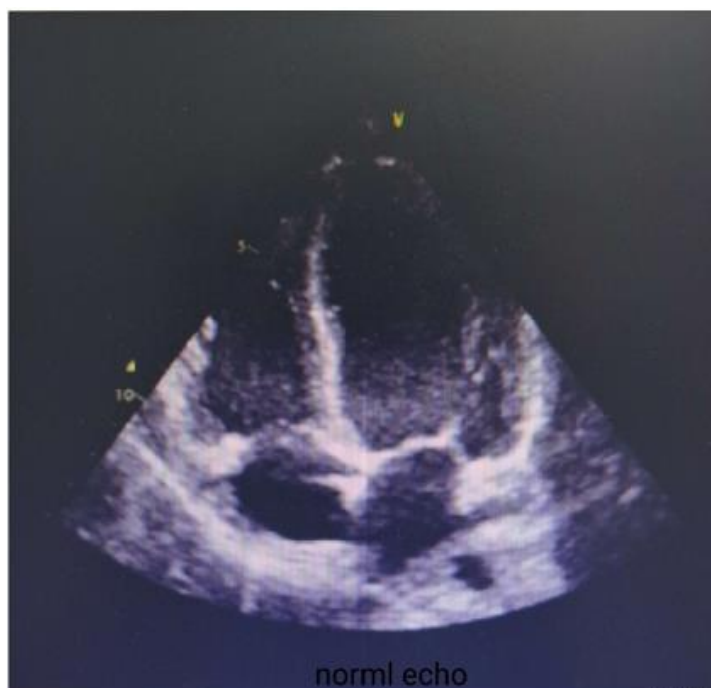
Showed Apical 4 Chamber view of 2D echocardiography with normal findings
